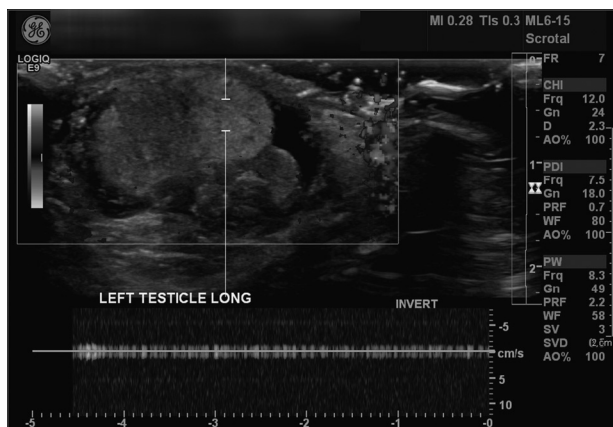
Color Doppler ultrasound study demonstrating no blood flow to the left testicle.
